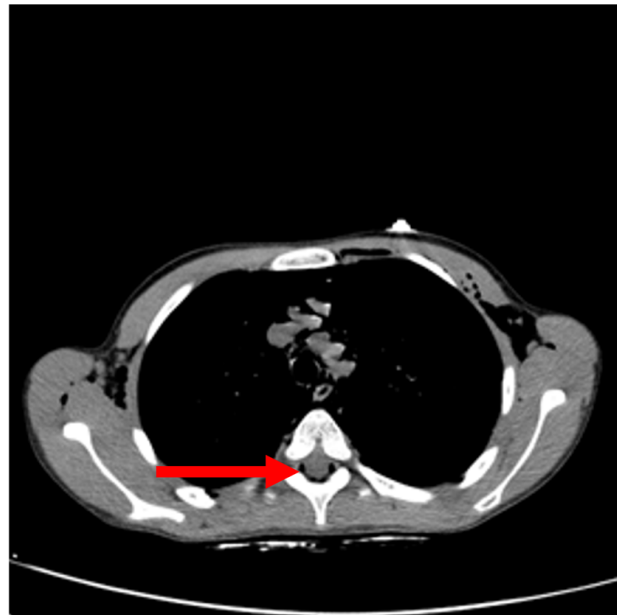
Chest CT (transverse section) showing small gas collections (red arrow) within the spinal canal.
